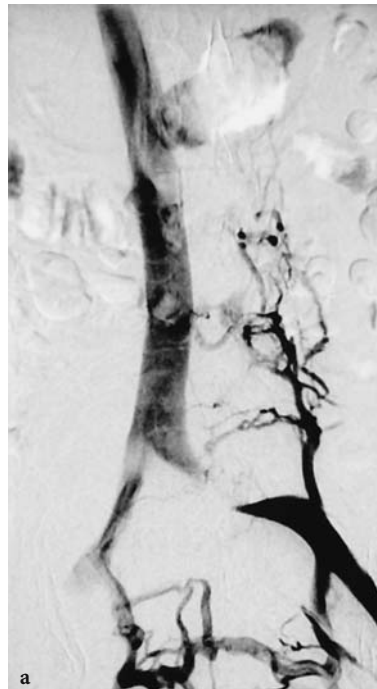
a Ascending Venogram demonstrating a focal left common iliac vein extrinsic stenosis and abundant collaterals. a CT confirms that the extrinsic stenosis is secondary to compression from the overlying left common iliac artery typical of May-Thurner syndrome
